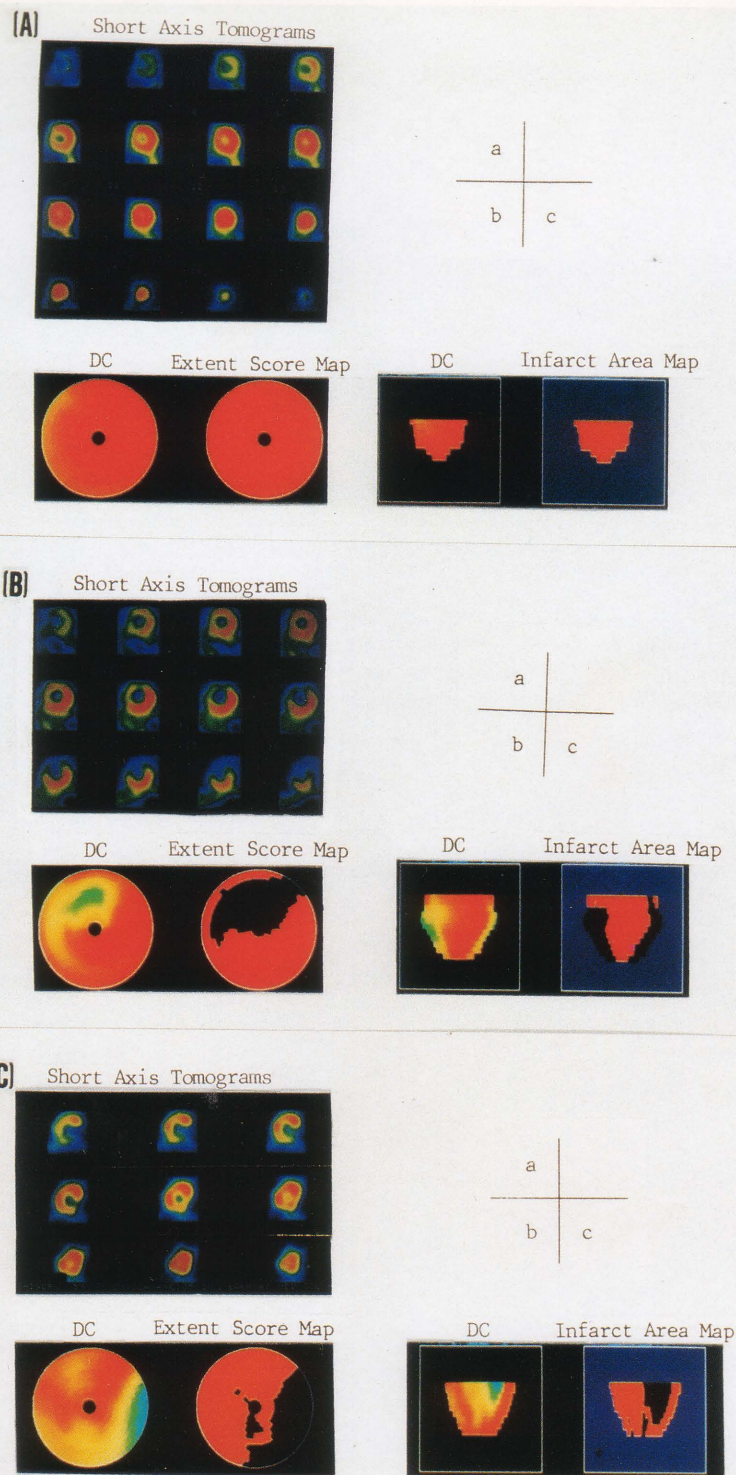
Demonstration of thallium-201 SPECT imaging, short axis tomograms (a), bull's eye view map (b) and unfolded surface map (c). (A) A typical image in a normal case. The septal segment seems to be a slightly hypoperfused area in the direct count (DC) image because of the existence of the membranous portion of the septum, while the bull's eye view map and unfolded surface map appear uniformly red. (B) SPECT images from a 57-year-old female patient with anteroseptal infarction. The infarct area is 27cm^2 and the extent score is 40%. (C) SPECT images from a 53-year-old male patient with posterolateral infarction. The infarct area is 34cm^2 and the extent score is 31%.
